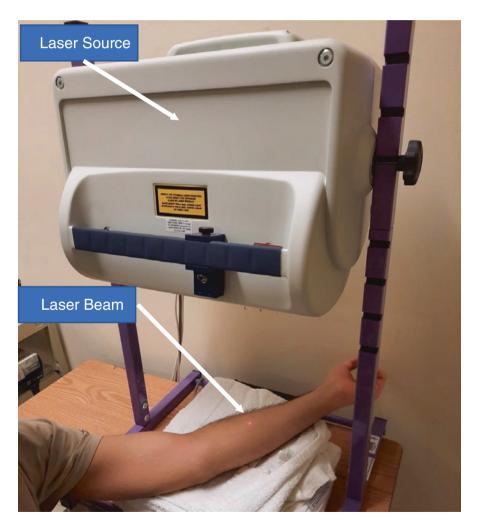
Laser Doppler imaging: A laser beam is emitted from the laser source to sequentially scan a chosen skin area. We employ the scanner to evaluate the area in which hyperemia is produced by the iontophoresed vasoactive substance on the volar surface of the forearm
